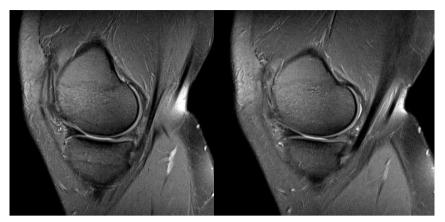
Knee MRI (April, 2016)
